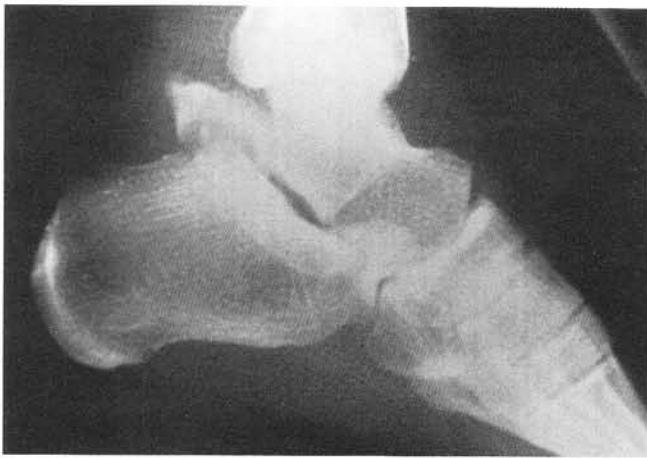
Lateral radiograph.
